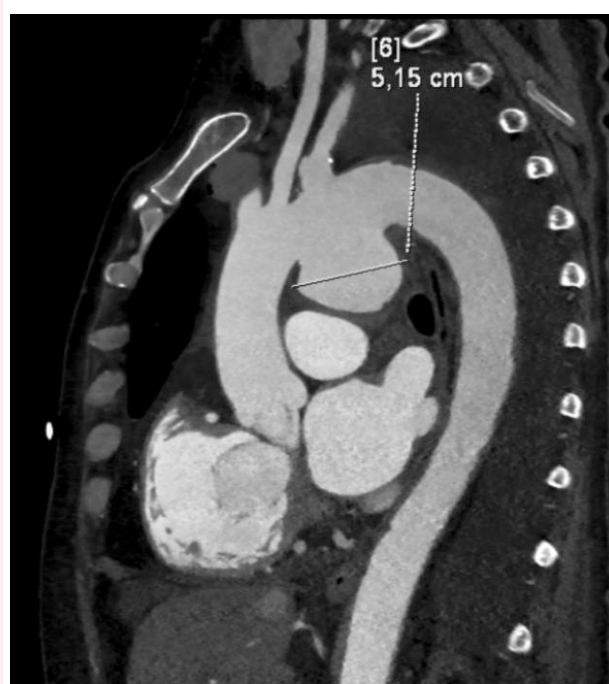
Contrast-enhanced CT angiography showing a saccular aneurysm of the aortic arch along its concavity, arising distal to the origin of the left common carotid artery, measuring 5 cm × 6 cm.
